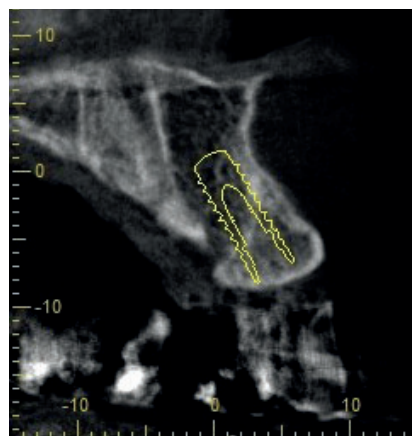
CBCT planning prior to implant placement.
